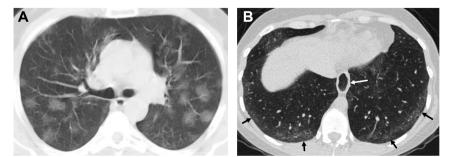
(A) A 55-year-old female patient with a diagnosis of COVID-19 pneumonia, axial chest CT image shows multifocal ground-glass opacities in both lungs and focal healthy lung areas between opacities. (B) A 38-year-old female patient with a diagnosis of systemic sclerosis, axial chest CT image shows ground-glass opacities (black arrows) with continuity in both lung lower lobes, compatible with nonspecific interstitial pneumonia. Note the dilatation of the distal esophagus.
